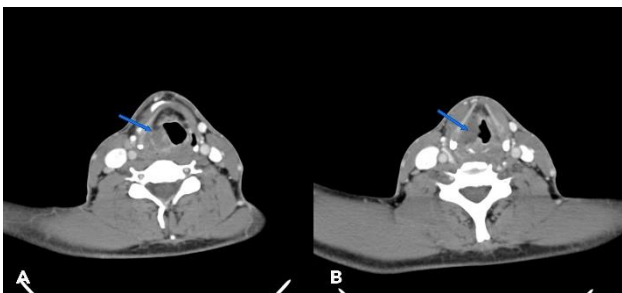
CT scan (axial views) after 1 week of initial observation showing a hypodense mass arrow in the right aryepiglottic fold (A) and the previous lesion in glottis/subglottic area with augmented dimensions (B).
